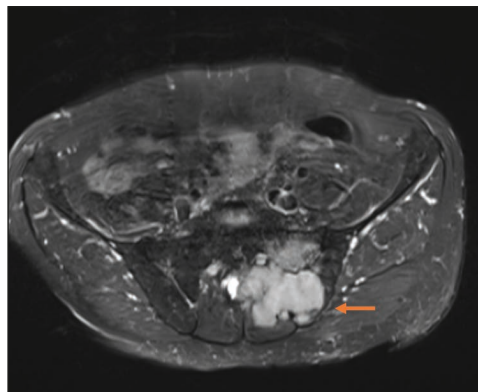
Fat suppressed T2 magnetic resonance imaging sequence: hyperintense (orange arrow) lesion at the left wing of the second sacral vertebra, involving and obliterating the sacral foramen, with transarticular involvement of the ilium, denoting a massive metastasis.
